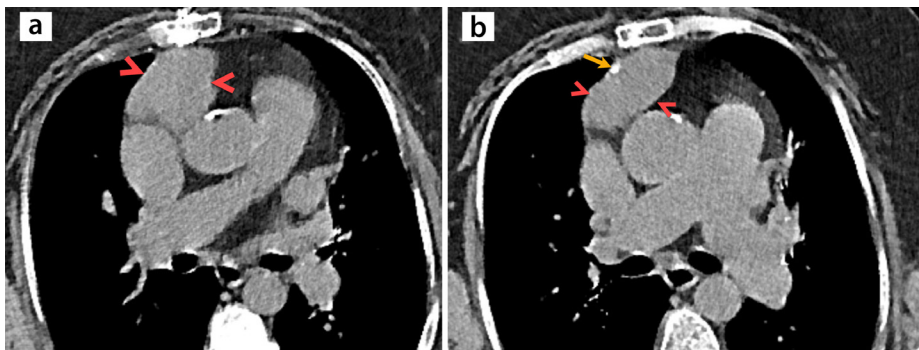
(a, b) A 78-year-old female patient with a history of coronary artery bypass grafting, recurrent pulmonary thromboembolism, and chronic kidney disease referred for unenhanced chest computed tomography (CT) because of abnormal findings on echocardiography. (a, b) Consecutive axial CT images demonstrating a right atrial outpouching (arrowheads), including calcification (arrow). The diagnosis of the right atrial pseudoaneurysm was pathologically confirmed, and the calcification was found to be consistent with chronic thrombus.
